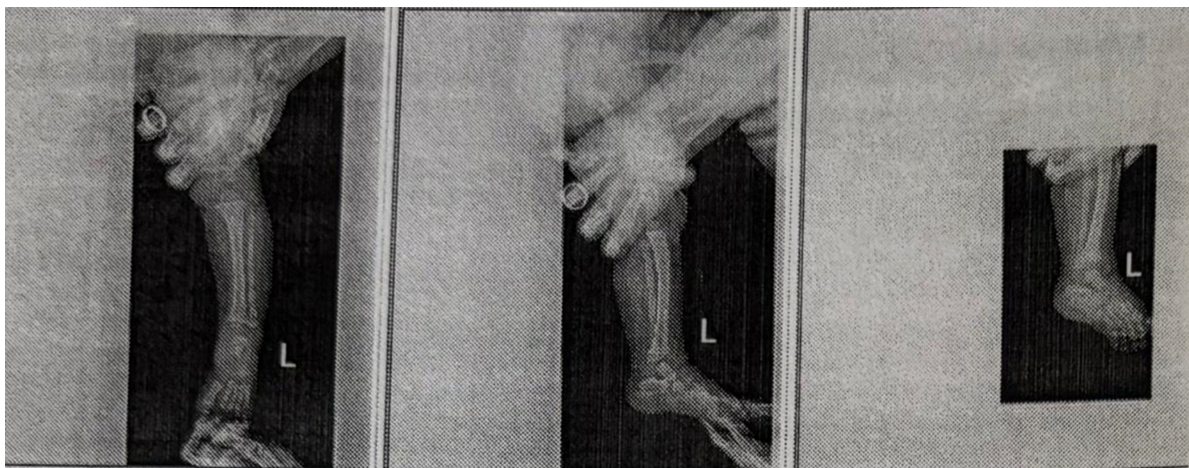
X-ray of the left ankle joint.
